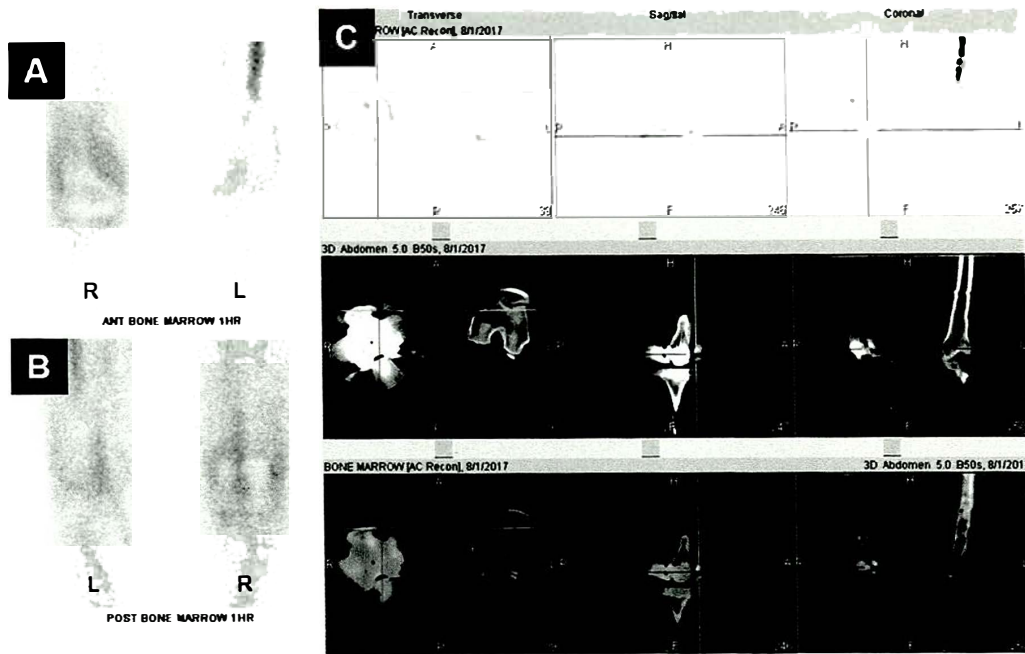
Planar [A-B] and SPECT/CT [C] images from bone marrow scintigraphy obtained 1 hour after ^{99m}Tc -sulfur colloid injection showed diffusely increased tracer uptake anterior to the right knee. The femoral and tibial prosthetic components exhibited uniform tracer distribution.
